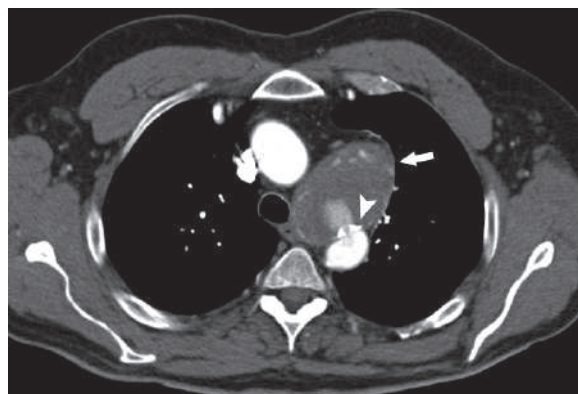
Axial cardiac CTA shows an area of aortic wall ulceration of the descending thoracic aorta (arrowhead) with a jet of bleeding into the aortic wall creating a periaortic mediastinal hematoma (arrowhead)
